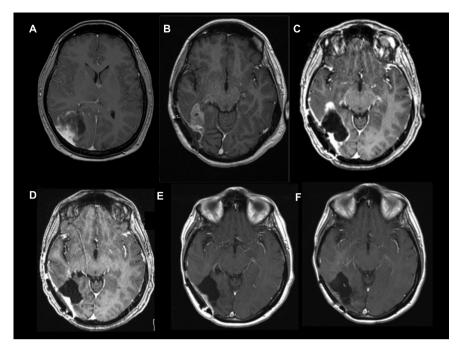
T1, contrast enhanced, axial MRI. A: anaplastic pleomorphic xanthoastrocytoma at diagnosis (17.1.2012), contrast enhanced tumorwith cystic component, B: prior to 3th surgery (26.11.2013), C: one month after 3th surgery (27.12.2013), D: five weeks on vemurafenib (31.1.2014), E: five months on vemurafenib (14.5.2014), F: one year on vemurafenib (22.1.2015).
